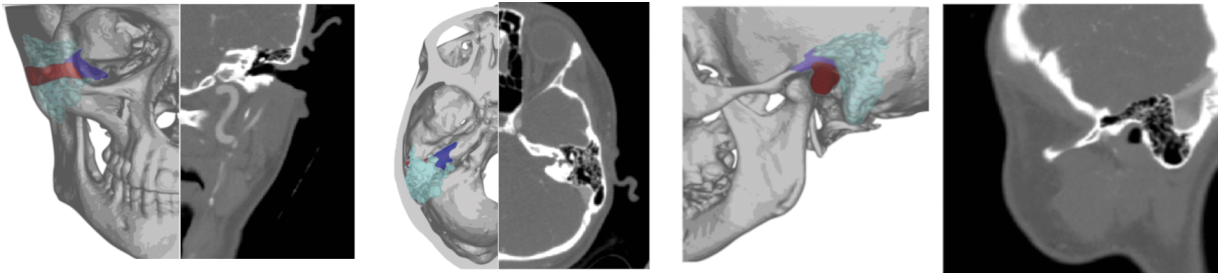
Three-dimensional representation of the studied region with computed tomography cross-section; red — external auditory canal; violet — tympanic cavity; turquoise — mastoid air cells.
